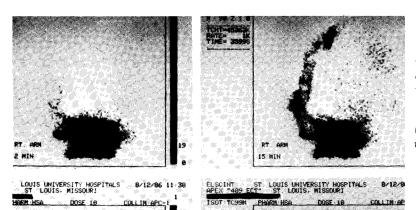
Lymphoscintigraphy images 2-60 minutes after injection of forearm melanoma: note early epitrochlear node uptake, axillary nodes at 15 minutes, and supraclavicular nodes at 45 minutes but minimal systemic background by 60 minutes.
